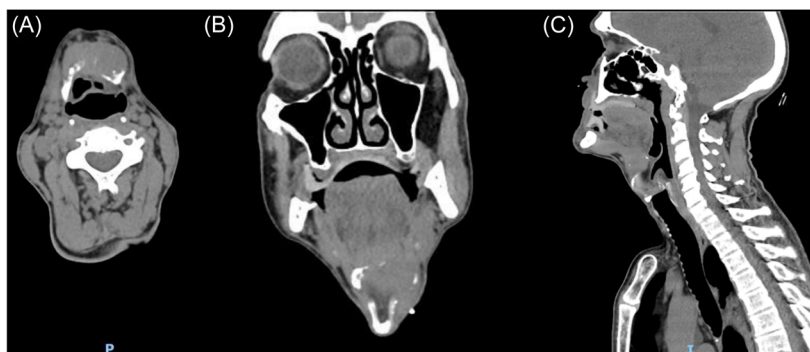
Preoperative computed tomography (CT) scan. (A) Axial view of the CT scan, showing extensive destruction of the hyoid bone by the mass, and the proximity of the mass to the vallecula. (B) On coronal view, the mass had extensive destruction and invasion to the surrounding tissue, including the hyoglossus muscle. (C) Sagittal view of the invasive mass shows the tumor had extension to the pre-epiglottic space by invading the posterior floor of the mouth.
